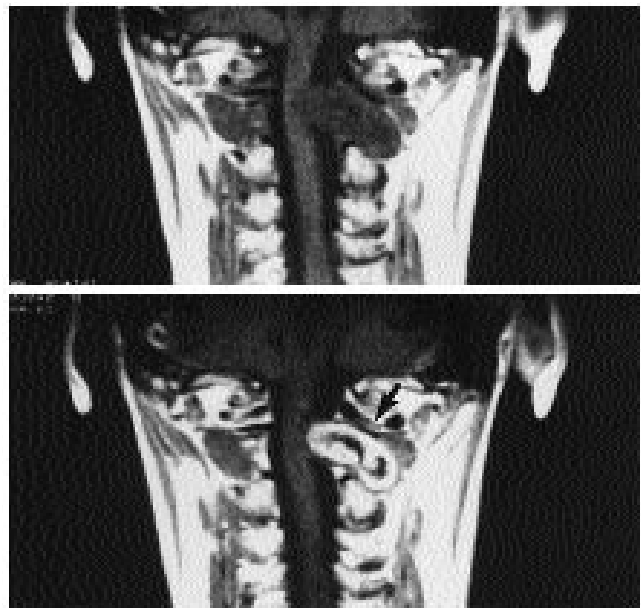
Magnetic resonance images showing an extraintradural neurinoma of the C-2 nerve root before (*upper*) and after (*lower*) gadolinium injection. Notice the relation with the vertebral artery (*arrow*).
